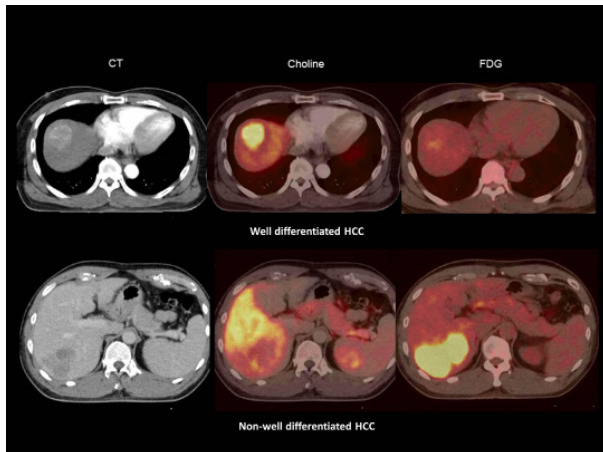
Imaging Findings. Two patients with HCC demonstrated on contrast-enhanced CT, the first row shows C-11 choline avid well-differentiated HCC lesion which demonstrates almost no F-18 FDG uptake. The second row shows a large moderately differentiated HCC which demonstrates intense F-18 FDG uptake but no C-11 choline uptake
